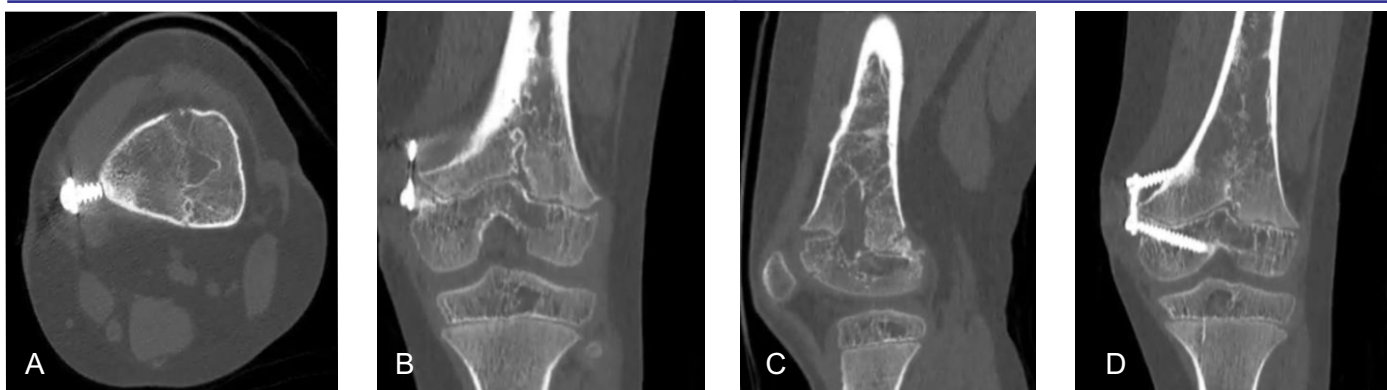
(A-C) Repeated CT scan of the left knee was performed 2 years after the bar physeal excision and 8-plate insertion. There was no reformation of the bar observed. However, the integrity of the fat graft used was not able to be seen from this study. (D) The 8-plate used for hemiepiphysiodesis still maintained at its original position, while the proximal screw might have slight backward migration.
